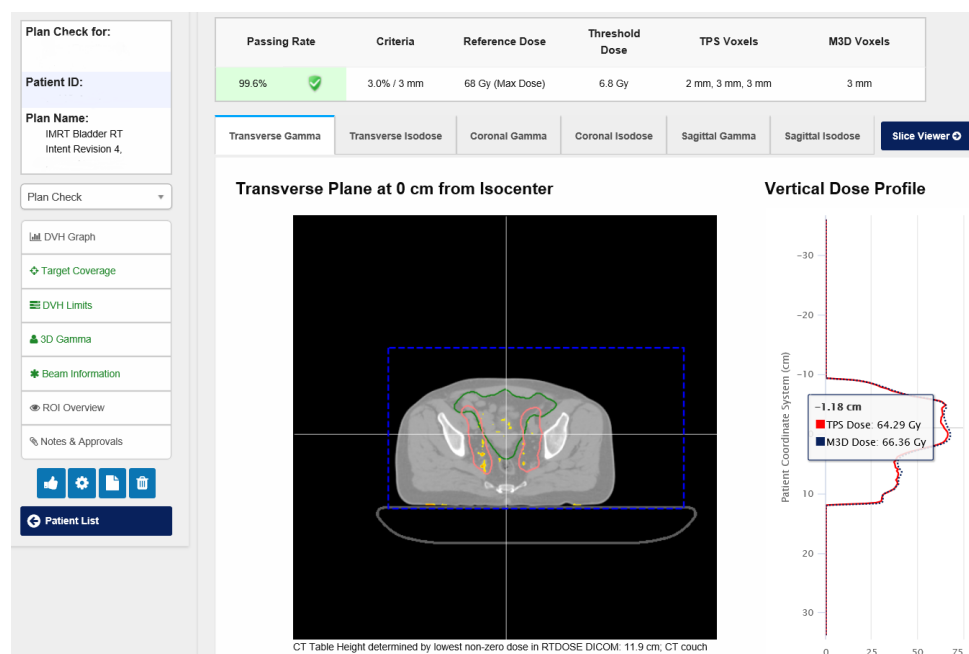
Representation of Mobius Adapt software. The figure shows transverse synthetic CT slice exported from adaptive session of bladder cancer patient. In the upper right corner patient's information can be found including fraction details. In the lower right corner different features can be viewed, such as DVH, target coverage and beam information. Gamma passing rate together with corresponding criterion showed in the upper middle of the figure. On the figures right one can see vertical dose profile that compares instantly calculated dose in Mobius Adapt to calculated Ethos dose.
